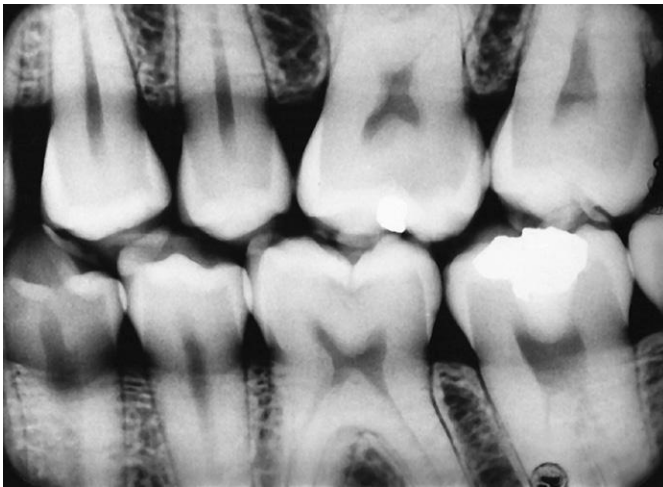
Bitewing radiograph showing occlusal caries in dentine in the lower first molar.
